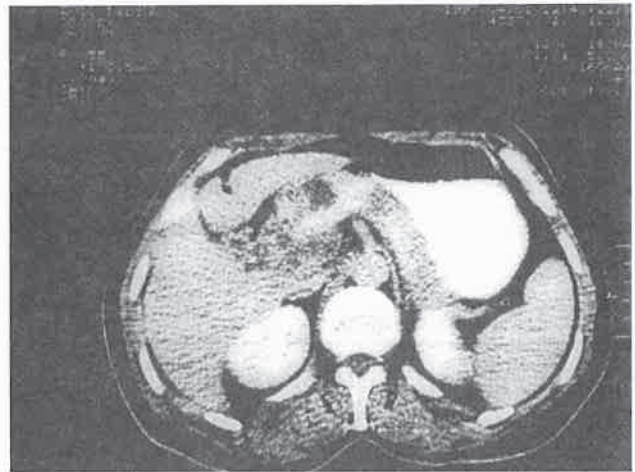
Lobulated mass lesion with heterogenous echo pattern on abdominal CT.
